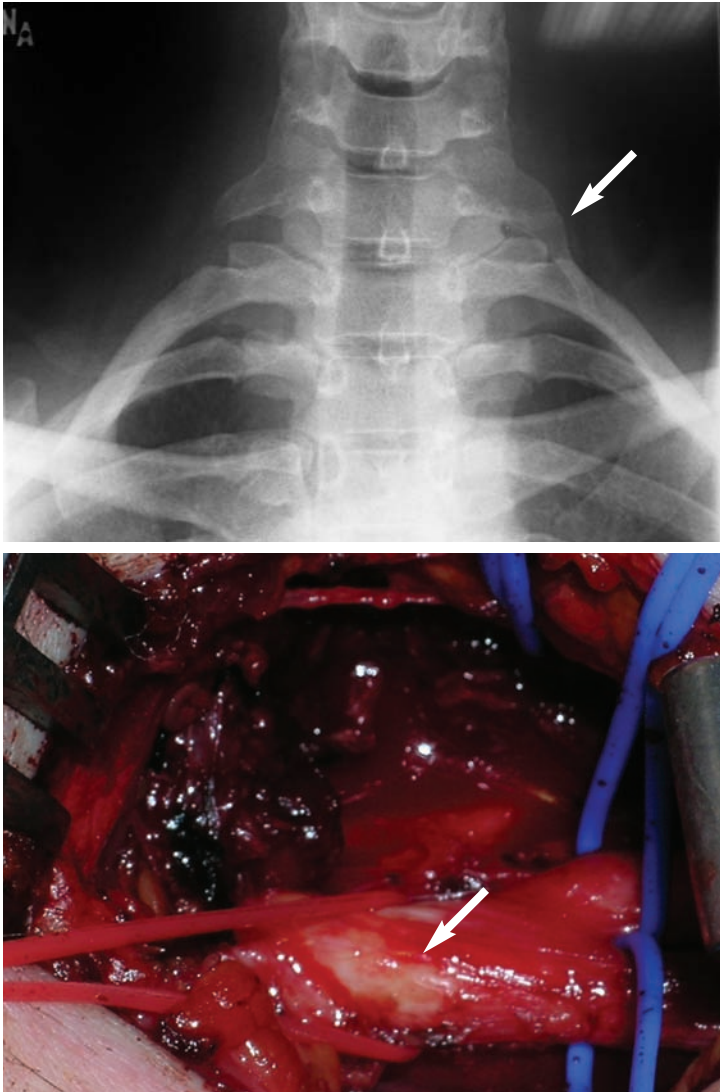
The x-ray (top) demonstrates a cervical rib, an extra rib, on the left side. This can cause compression of the brachial plexus and give thoracic outlet symptoms. In this case, that extra rib must be removed. This is shown in surgery (bottom).
